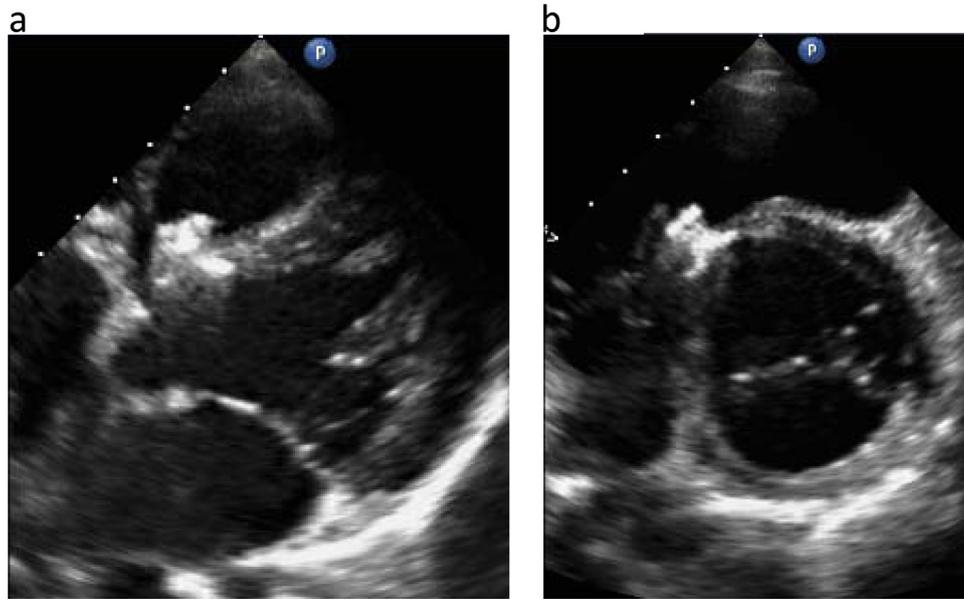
Transthoracic echocardiography after the procedure at four-chamber view (a) and short-axis view (b).
